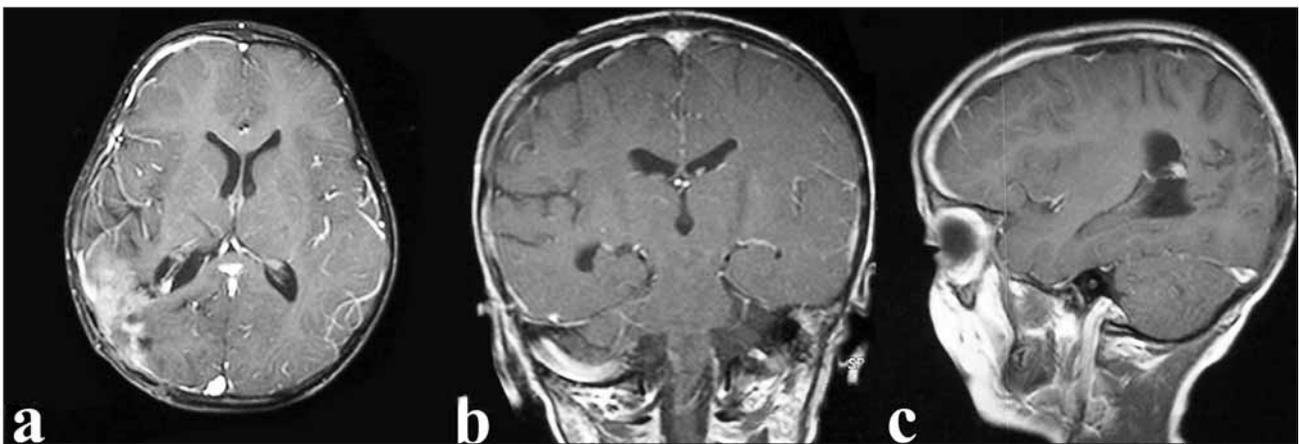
Early postoperative axial (A), coronal (B) and sagittal (C) contrast enhanced cranial MRI sections demonstrate near total removal with postoperative changes.
